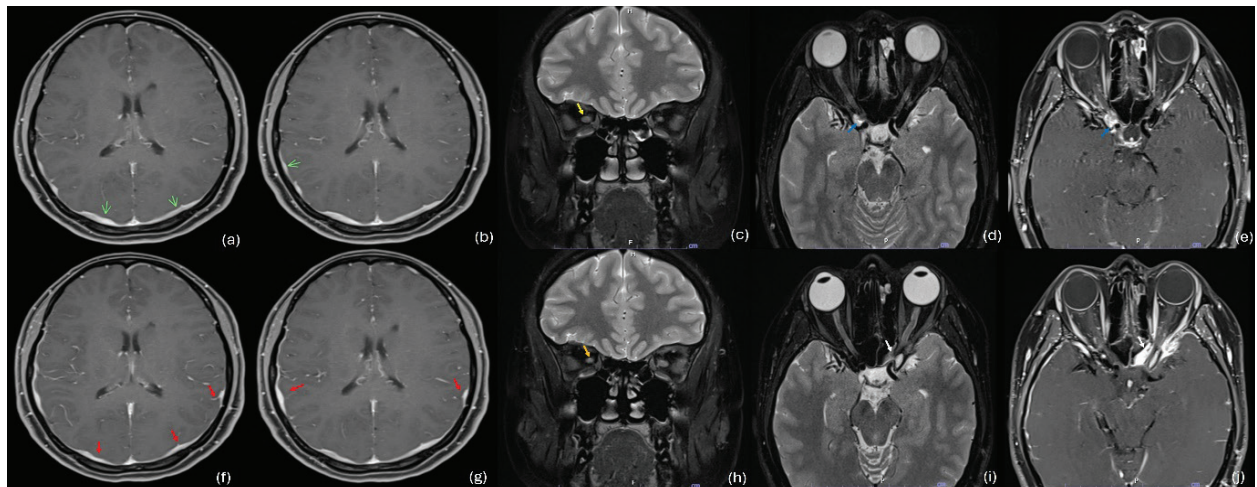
Contrast-enhanced MRI brain and orbit with comparison between the 1st episode (a-e) and 2nd episode (f-j): (a,b) axial view T1FS shows multifocal dural thickening along bilateral parietooccipitotemporal convexities (green arrow), (c) coronal view T2FS shows the right optic nerve (yellow arrow), (d) axial view T2FS shows a faint hyperintense right optic nerve (blue arrow), (e) axial view T1 FS with gadolinium shows focal enhancement at the right intracanalicular optic nerve with an enhancement of the optic nerve sheath and thin dural thickening along the right anterior clinoid process (blue arrow), (f, g) progression of multifocal dural thickening (red arrow), (h) a decrease in size of the right optic nerve (orange arrow), (i) a faint hyperintense left optic nerve (white arrow), (j) focal enhancement is noted at the left intracanalicular optic nerve with an enhancement of the optic nerve sheath, and thin dural thickening along the left anterior clinoid process (white arrow).
